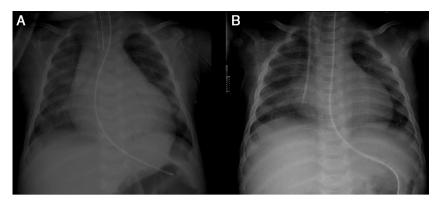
(A) Chest X-ray at admission showing cardiomegaly (cardiothoracic ratio 80%); (B) chest X-ray on day 25, showing reversal of cardiomegaly with treatment (cardiothoracic ratio 52%).
